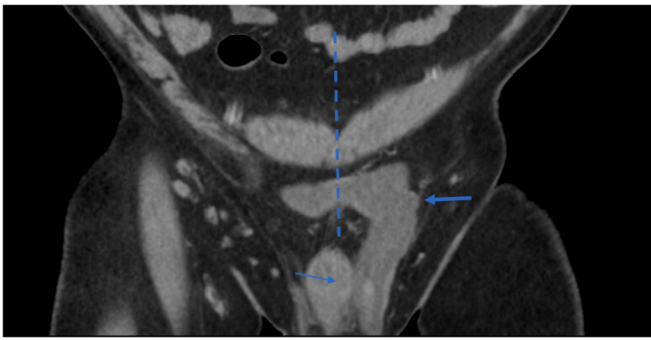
Coronal view of Computerized Tomography (CT) of the pelvis. CT demonstrated large heterogenous lesion (bold arrow) adjacent to the left corpora cavernosum and crossing anatomical midline (dash blue line).
